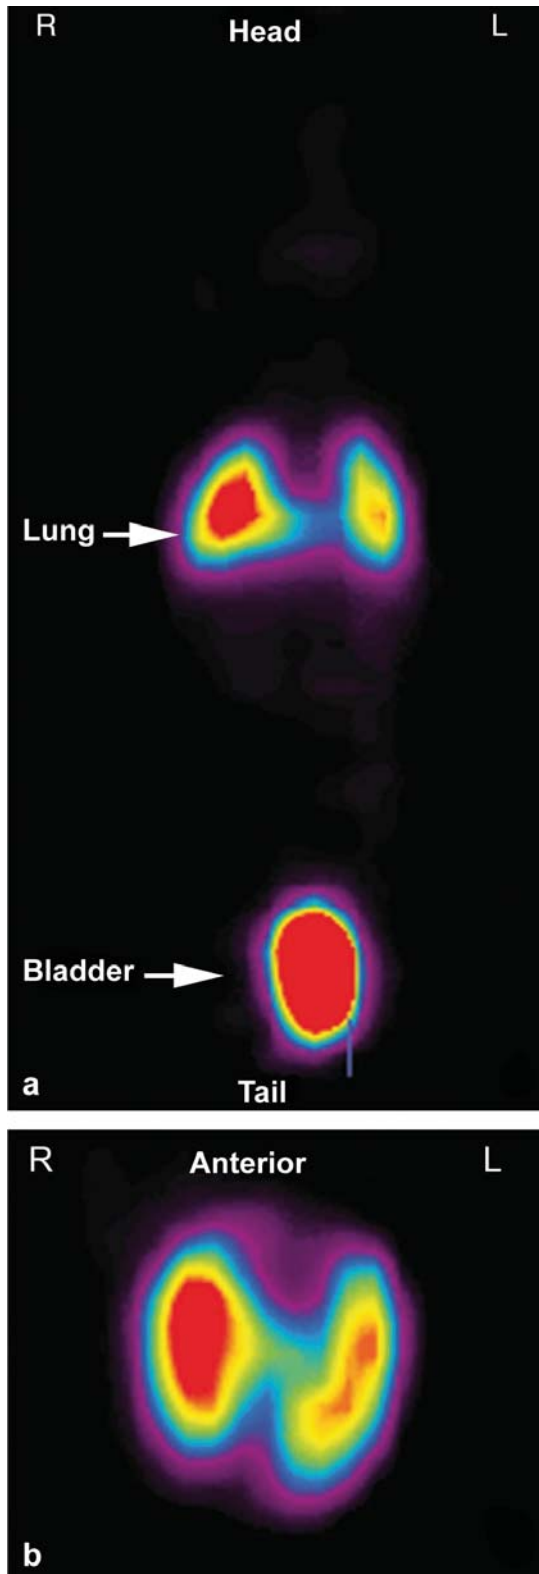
Coronal (a) and transaxial (b) positron emission tomography (PET) slices showing the biodistribution of 2'-[ $^{18}\text{F}$ ]-2'-deoxy-D-glucose (FDG)-labelled MADB106 tumour cells 40 min post inoculation. Only lung and urinary bladder showed accumulation of activity.
